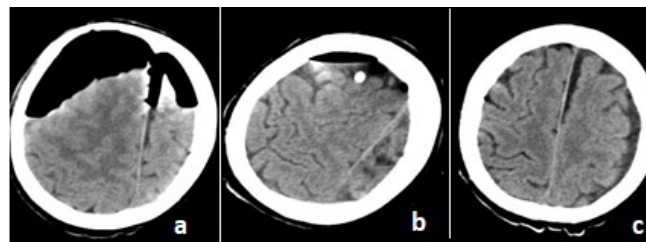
Brain CT scans; (a) initial pneumocephalus on postoperative day 5, (b,c) control.
